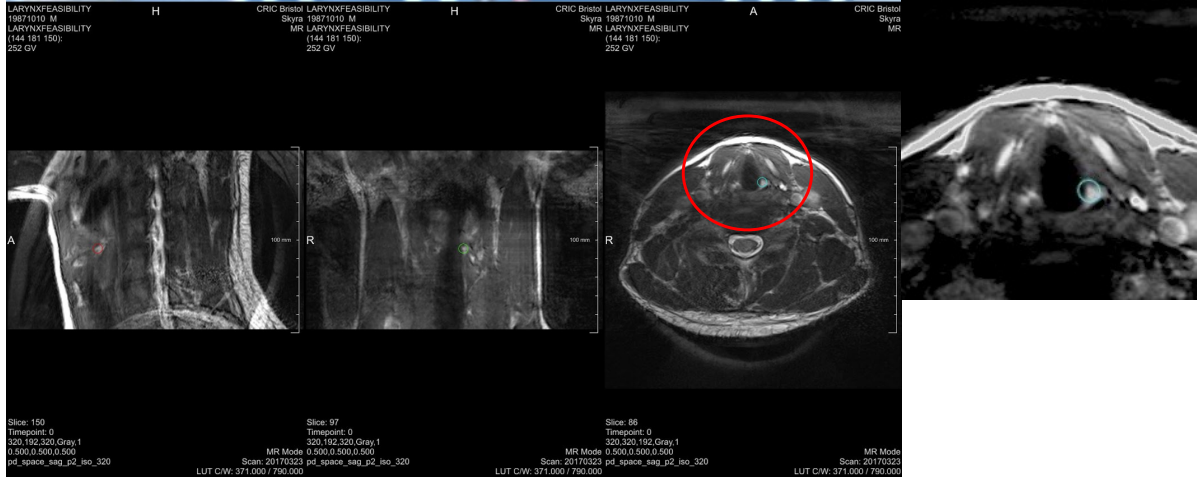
A sample MRI scan from subject.
